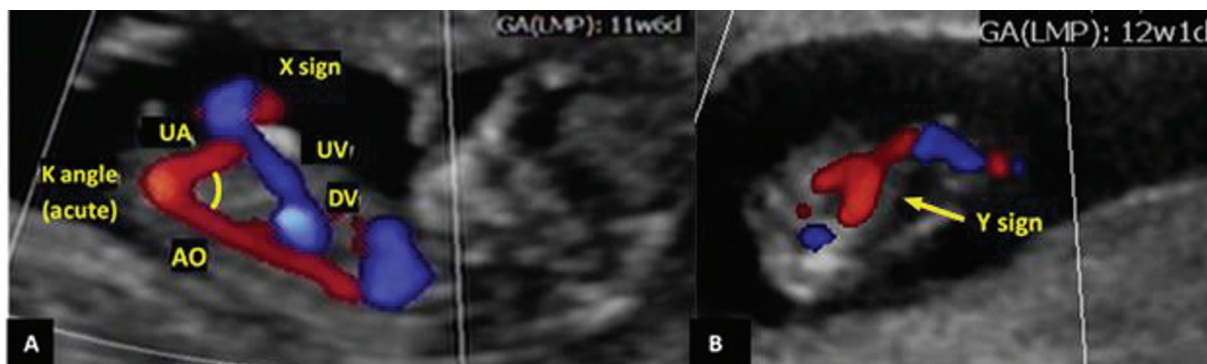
Color Doppler in a normal fetal abdomen—(A) Sagittal view shows equilateral triangle formed by aorta (AO), umbilical artery (UA), and umbilical vein (UV) at 12 weeks; acute “K angle”; “X-sign.” (B) Transverse-bladder view shows “Y-sign” at 12 weeks.
